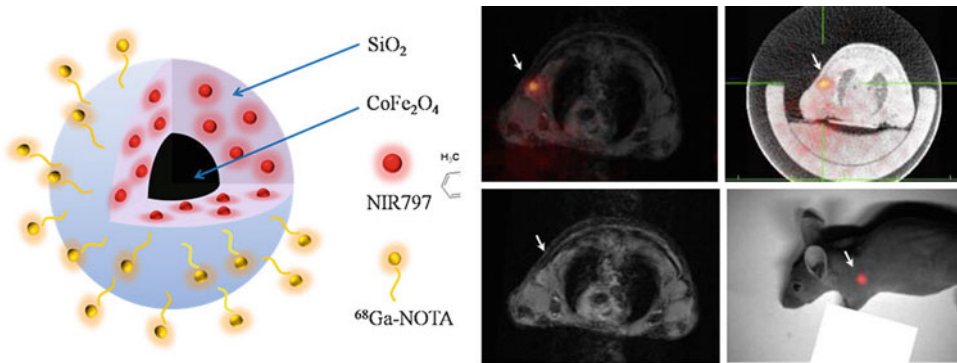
A multimodal probe containing radioisotope, iron-oxide, and fluorescent dye (a), PET/CT (c), MRI (d), and optical images (e) of the sentinel lymph node in a
